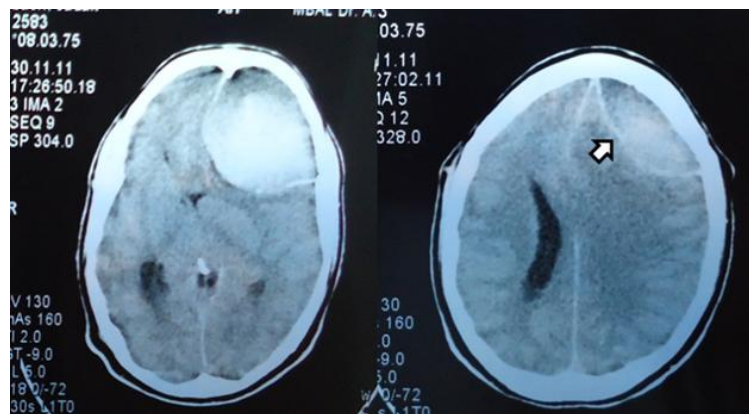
CT image of epidural abscess: (↔) capsule
